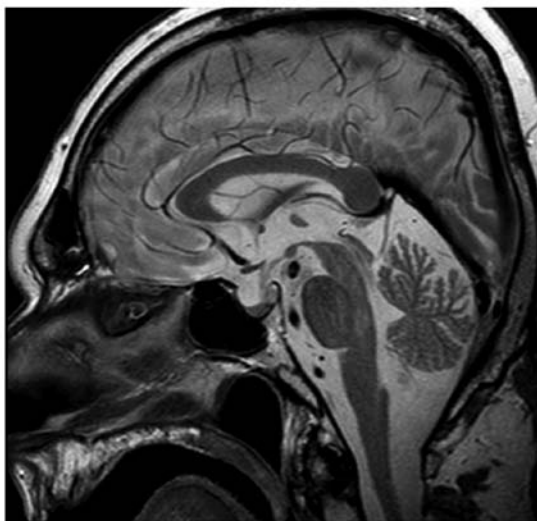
Pituitary magnetic resonance imaging T2 with no pathological findings.
